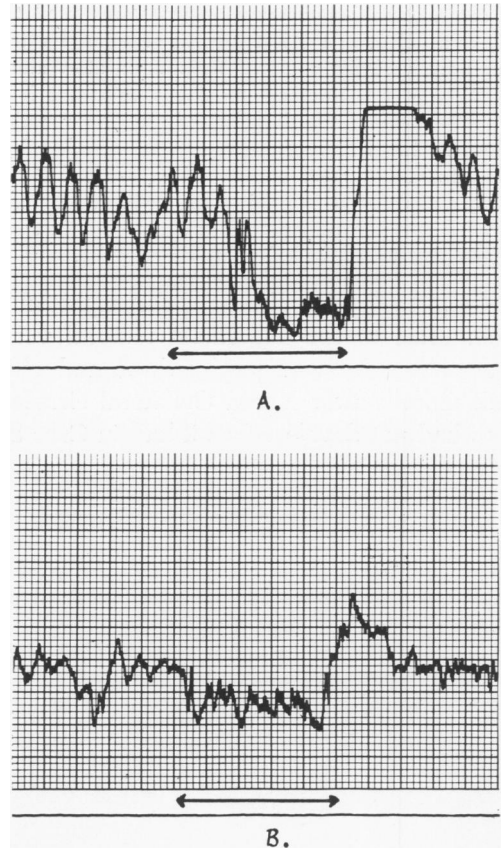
The ultrasonic sounding device (Doppler) records normal depression with rapid elevation (A) of the right common femoral vein after the Valsalva maneuver. In contrast this characteristic flow pattern was absent (B) when the Doppler was placed over the left common femoral vein (Case 10).
